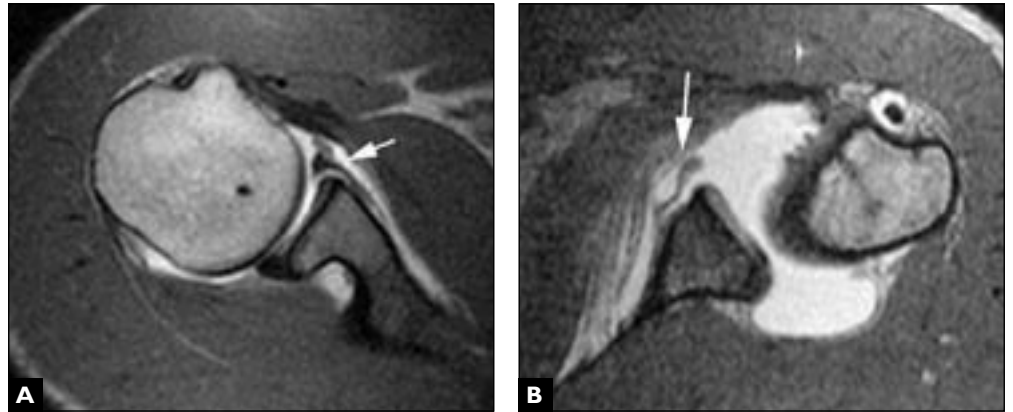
(A,B). MRI arthrogram in two different patients, shows a classic Bankart lesion (arrow in A) and an ALPSA lesion (arrow in B).
